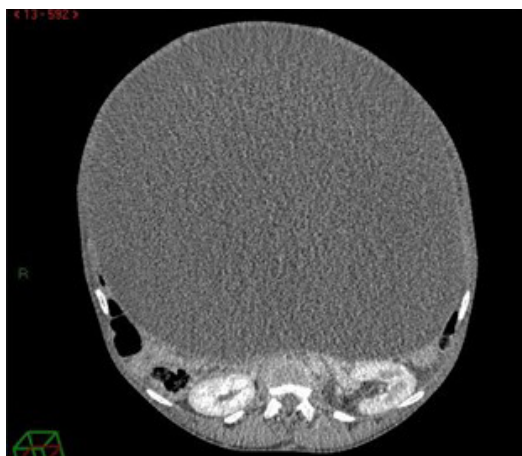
Abdominal CT – axial view of the tumor mass.
